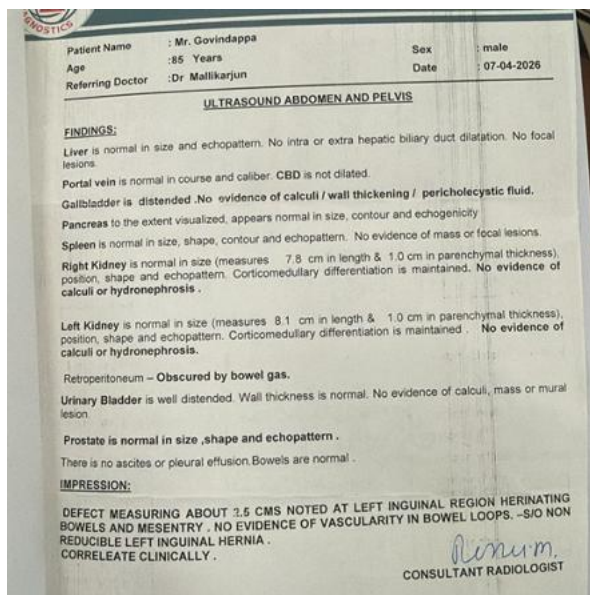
Ultrasound report of the abdomen and pelvis showing Irreducible left inguinal hernia
